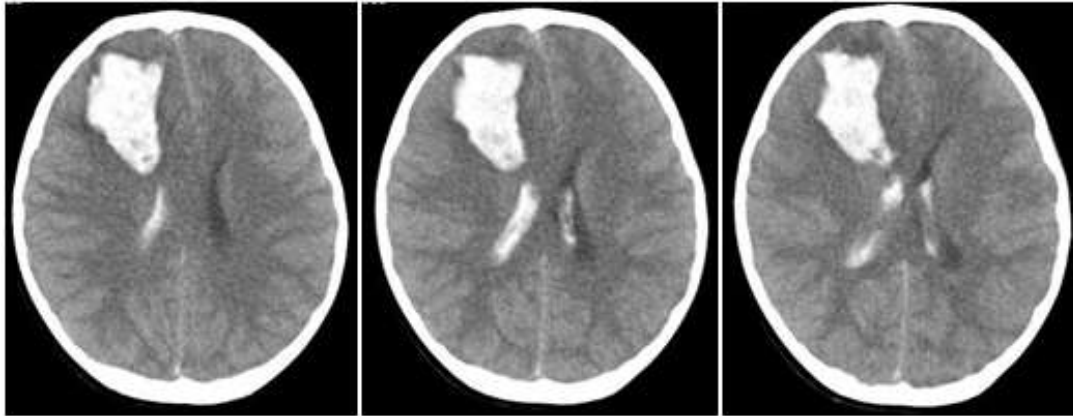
Cranial CT scan. Axial.
